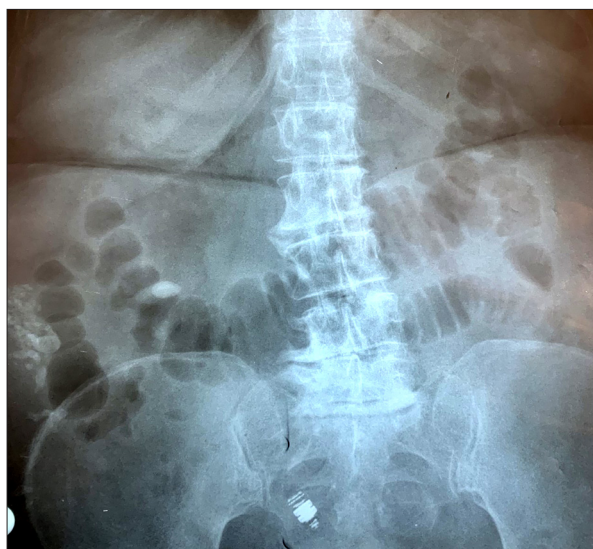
Plain abdominal radiography demonstrates a radiopaque lesion resembling endoscopic capsule in the lower abdomen.
